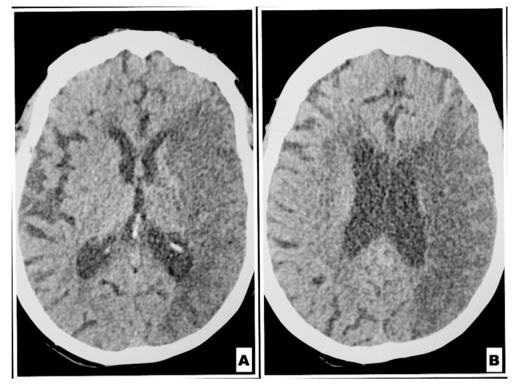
(A) 30 days follow-up non contrast brain computed tomography basal ganglial level; (B) 30 days follow-up non contrast brain CT corona radiata level. (B) 30 days follow-up non contrast brain CT corona radiata level.
